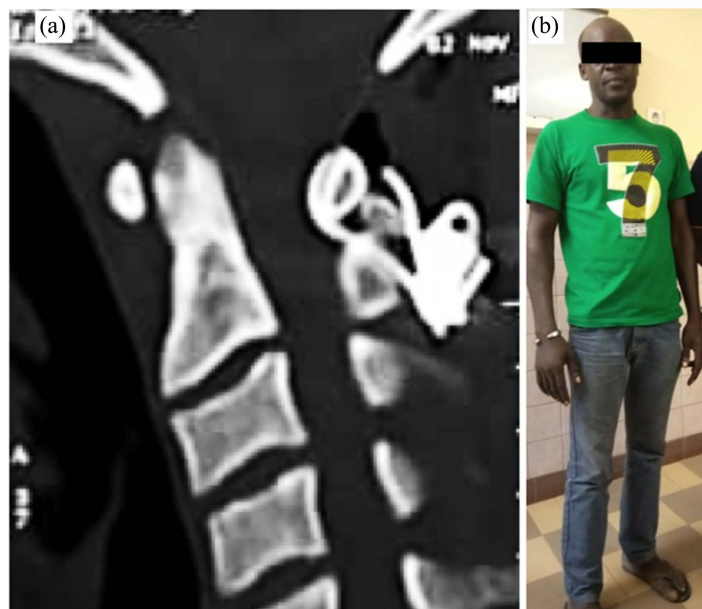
Case 1 Postoperative CT scan showing proper reduction of dislocation after wiring (a) and the patient at 45 postoperative days (b).
